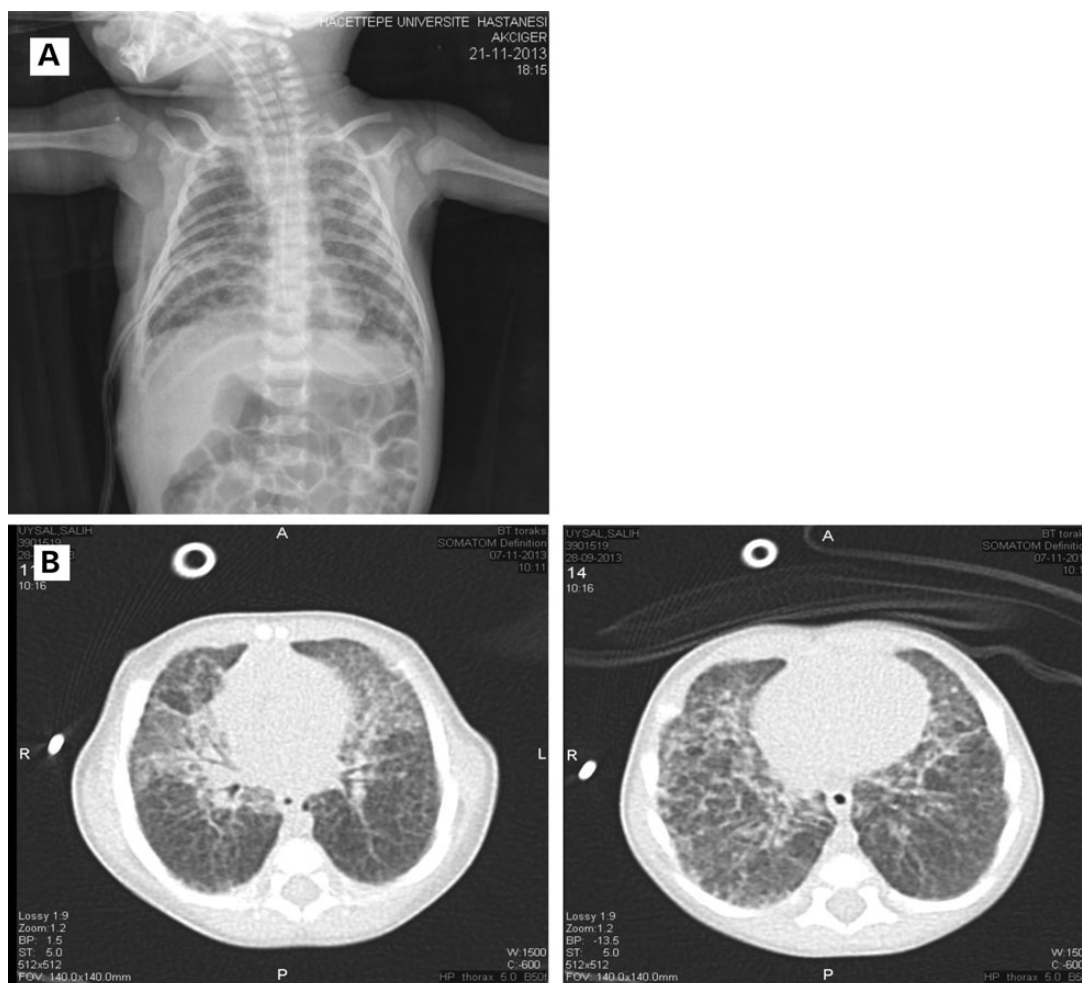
Radiological findings. (A) Chest radiography showed bilateral diffuse interstitial infiltrates at the age of 1.5 months. (B) Chest CT at the age of 1.5 months revealed diffuse ground glass opacity and interlobular septal thickening consistent with diffuse interstitial lung disease.
